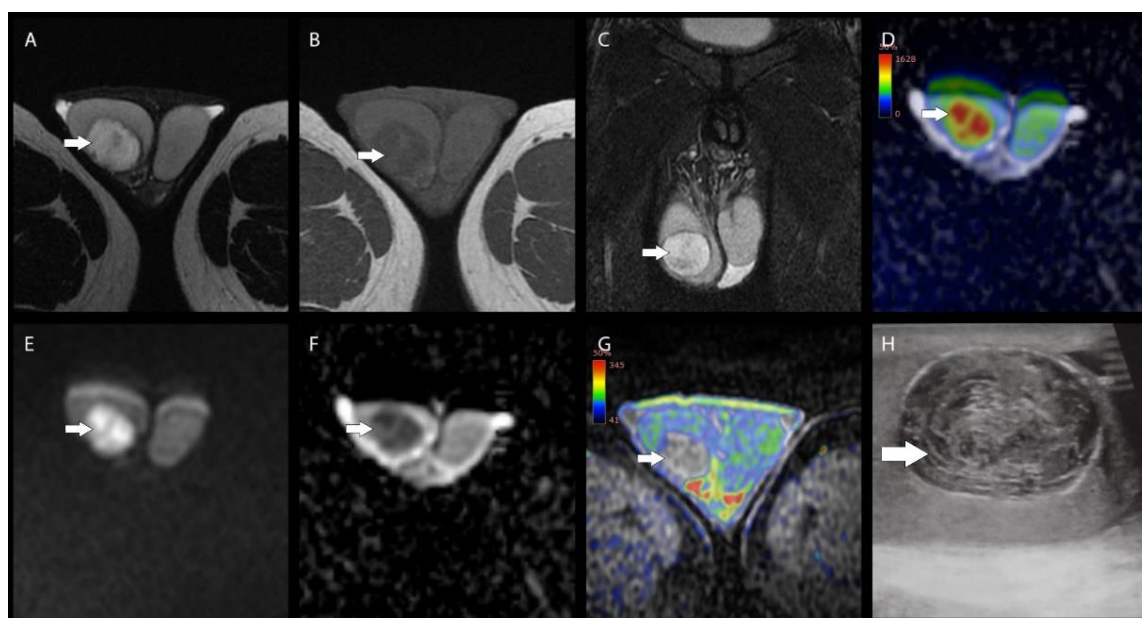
Patient 35 y.o., the right testicle 4.9x3x3.9 cm, in the middle third of the parenchyma, a clearly defined lesion is identified, hyperintense on T-2 and STIR, hypointense on T-1, with diffusion restriction, with decreased ADC, without contrast enhancement – MRI findings most characteristic of an epidermoid cyst. Multiparametric MRI, the lesion is marked with an arrow: A) axial T-2 weighted image; B) axial T-1 weighted image; C) coronal short tau inversion recovery image (STIR); D) axial fusion image between diffusion-weighted image and apparent diffusion coefficient map; E) axial diffusion-weighted image; F) axial apparent diffusion coefficient map; G) axial fusion image between precontrast T-1 weighted image and positive enhancement integral quantitative analysis of contrast enhancement over time in dynamic contrast-enhanced image; H) USG image.
